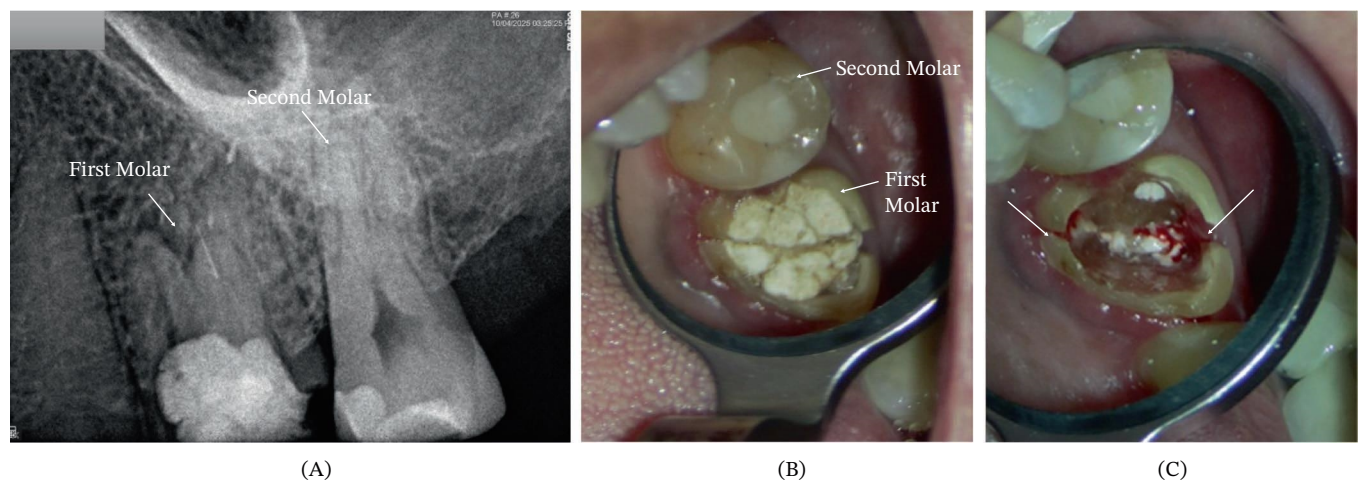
Preoperative radiograph (A) and intraoral photographs (B-C) of the maxillary first and second molars. The carious lesion is indicated by white arrows in the right photograph.
